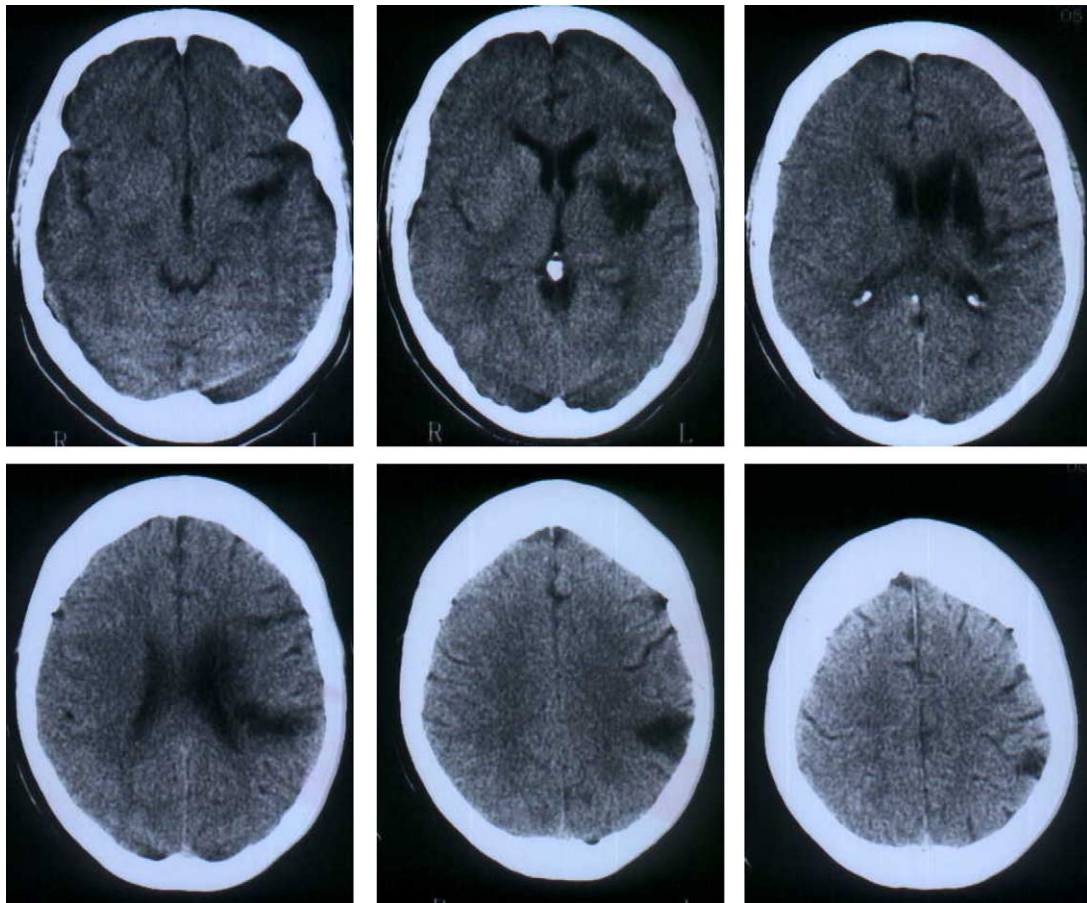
Patient AF's follow-up CT scan performed 8 weeks post-stroke onset. The lesion is confined to the territory of the left middle cerebral artery, involving the inferior parietal lobule, insula, external capsule, lentiform, and caudate nuclei, internal capsule and the periventricular white matter.
